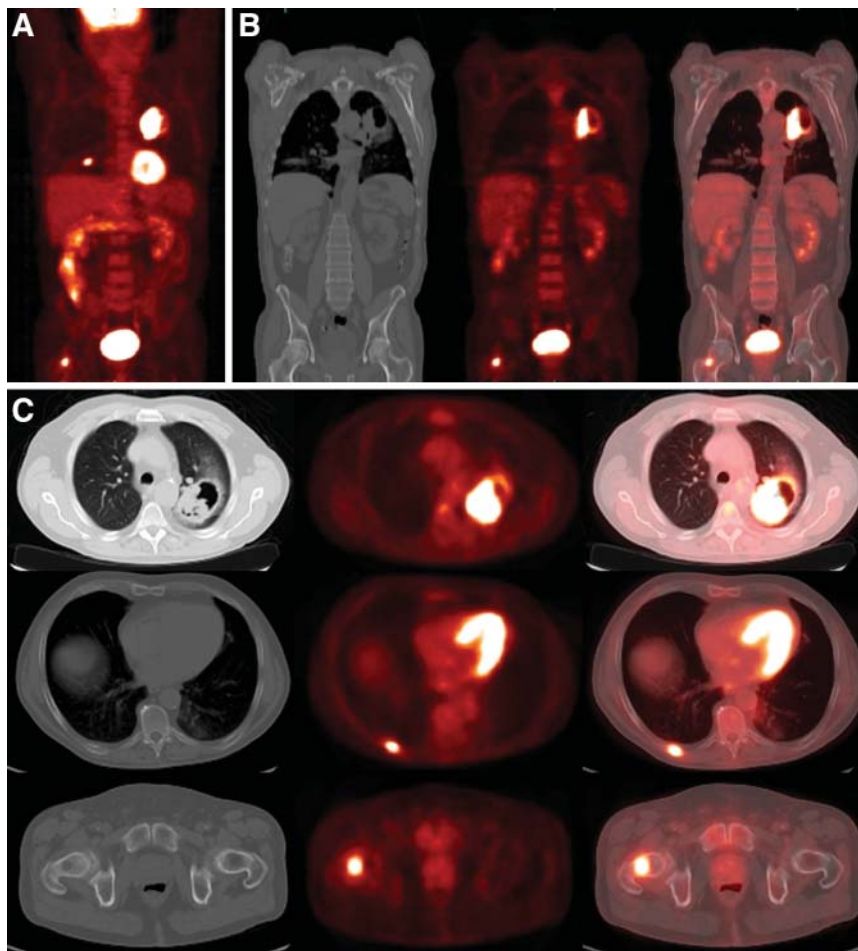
Lung cancer with osseous metastases. Hypermetabolic cavitory lung mass is seen in left upper lobe (A–C). Maximum-intensity-projection image (A) demonstrates additional lesions in contralateral thorax and hip. Additional focus of hypermetabolism is seen in right femoral neck (A–C) and corresponds to subtle lytic lesion on CT. Axial images (C) show hypermetabolism in right posterior 8th rib without osseous changes on CT.
